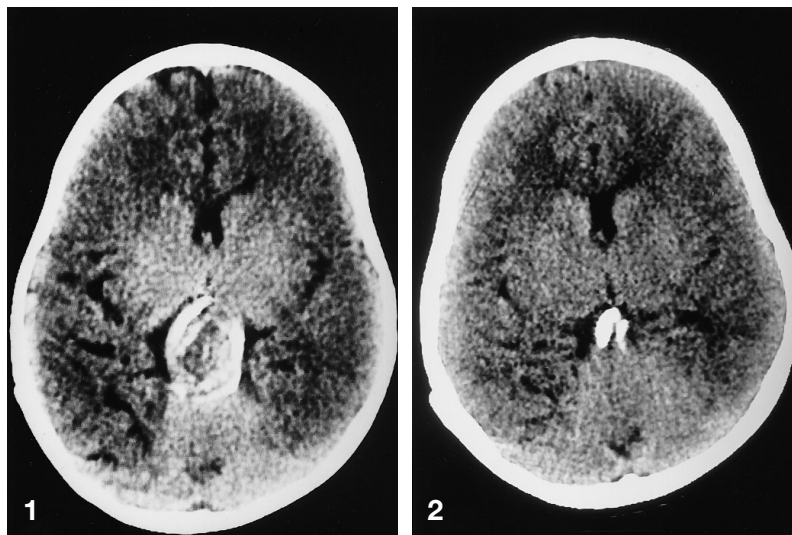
CT at 2 years 4 months shows ring calcification with a central organised thrombus
